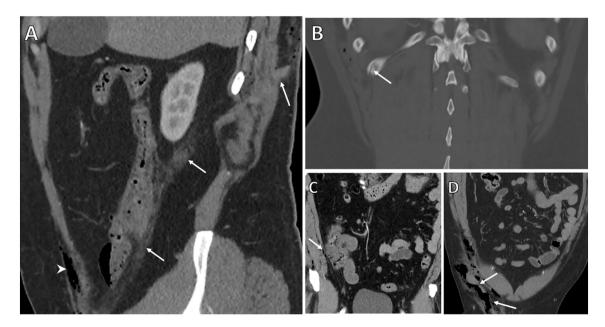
Intraperitoneal penetrating scrotal trauma. Sagittal (A) and coronal (B, C & D) CT abdomen post contrast in a 48-year-old male following scrotal impalement with a broom. A) The path of the impaled broom can be seen to follow a "tract" of inflammatory change in the right paracolic gutter (arrows) and pre-peritoneal gas (arrowhead), note the proximity of the ascending colon. B) In bone window setting, an associated non-displaced fracture of the right twelfth rib is apparent (arrow). C) Intraperitoneal free gas (arrow) adjacent to oedematous ascending colon concerning for bowel injury. D) demonstrates the volume of gas within the right inguinal canal (arrows).
